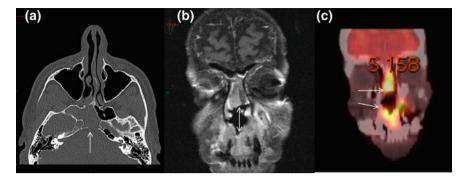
a SCC of the sphenoid sinus. Axial non-contrast CT demonstrating expansile sphenoid sinus mass with the erosion of posterior sinus wall (*arrow*). b, c Recurrent SCC of the sinonasal cavity. Coronal T1 post-contrast MRI shows heterogeneous enhancing tissue in the nasal cavity and maxilla (double arrows) which could be a tumor or less likely scar tissue. Coronal-fused PET-CT confirms residual tumor in both these areas
